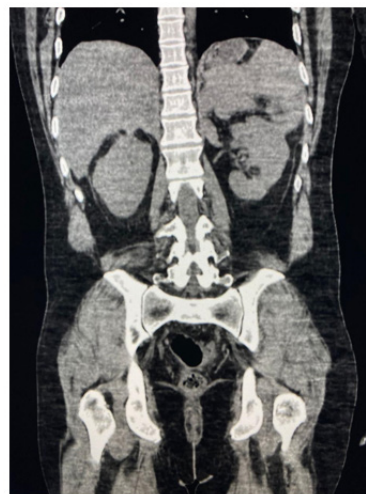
Computed Tomography of the Abdomen Showing Bilateral Adrenal Masses
